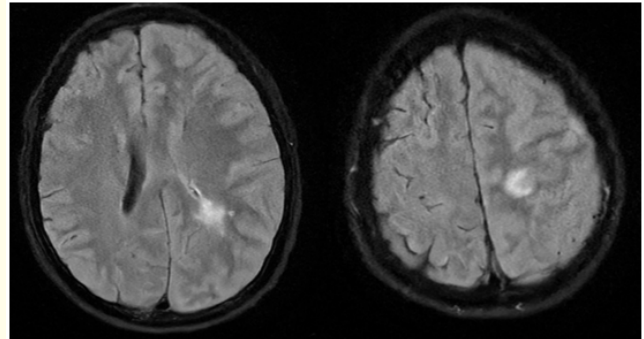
Cranial MRI showed T2/Flair hyperintensities along the left frontal and parietal lobe sulci. There are also hyperintense lesions at the juxtacortical region of the left precentral gyrus with minimal restricted diffusion and non-enhancement. The left cerebral sulci and fissures are effaced with compression of the left lateral ventricle. There is also noted cortical thickening at the left hemisphere.
